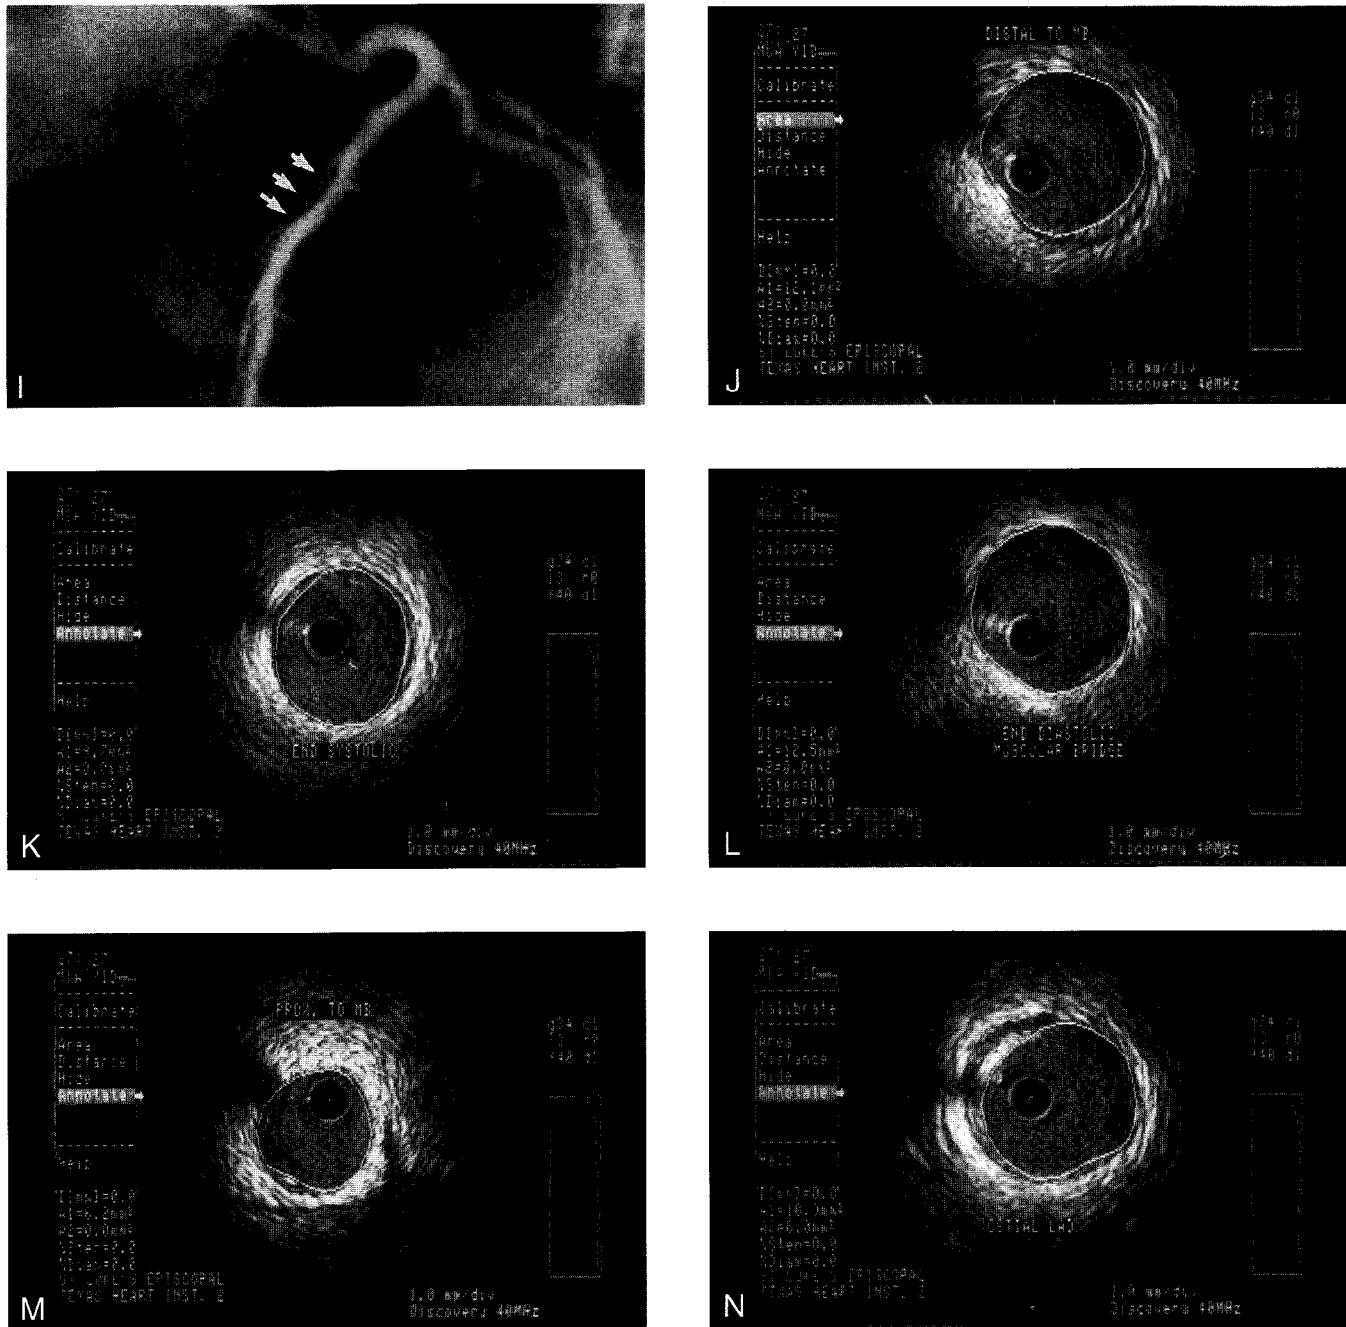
(Continued) I. Diastolic angiographic frame in the left anterior oblique projection, showing total resolution of spasm and the persistence of systolic narrowing at the muscular bridge. J–N. Intracoronary ultrasound images of the LAD, after intracoronary nitroglycerin administration, at the following sites: distal to the muscular bridge (J); at the muscular bridge (end-systole) (K); at the muscular bridge (end-diastole) (L); at the bend, proximal to the muscular bridge (M); and at the LAD ostium (just distal to the circumflex separation) (N). Note that passage of the ultrasound catheter caused spasm at the proximal LAD bend (view M), most likely because of mechanical stimulation. Area calculations are indicated in each view.
